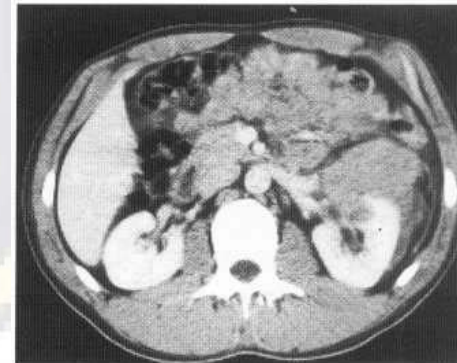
Contrast CT showing a laceration of the kidney in the vicinity of the anterior lip of the renal sinus with a large associated haemorrhage.
